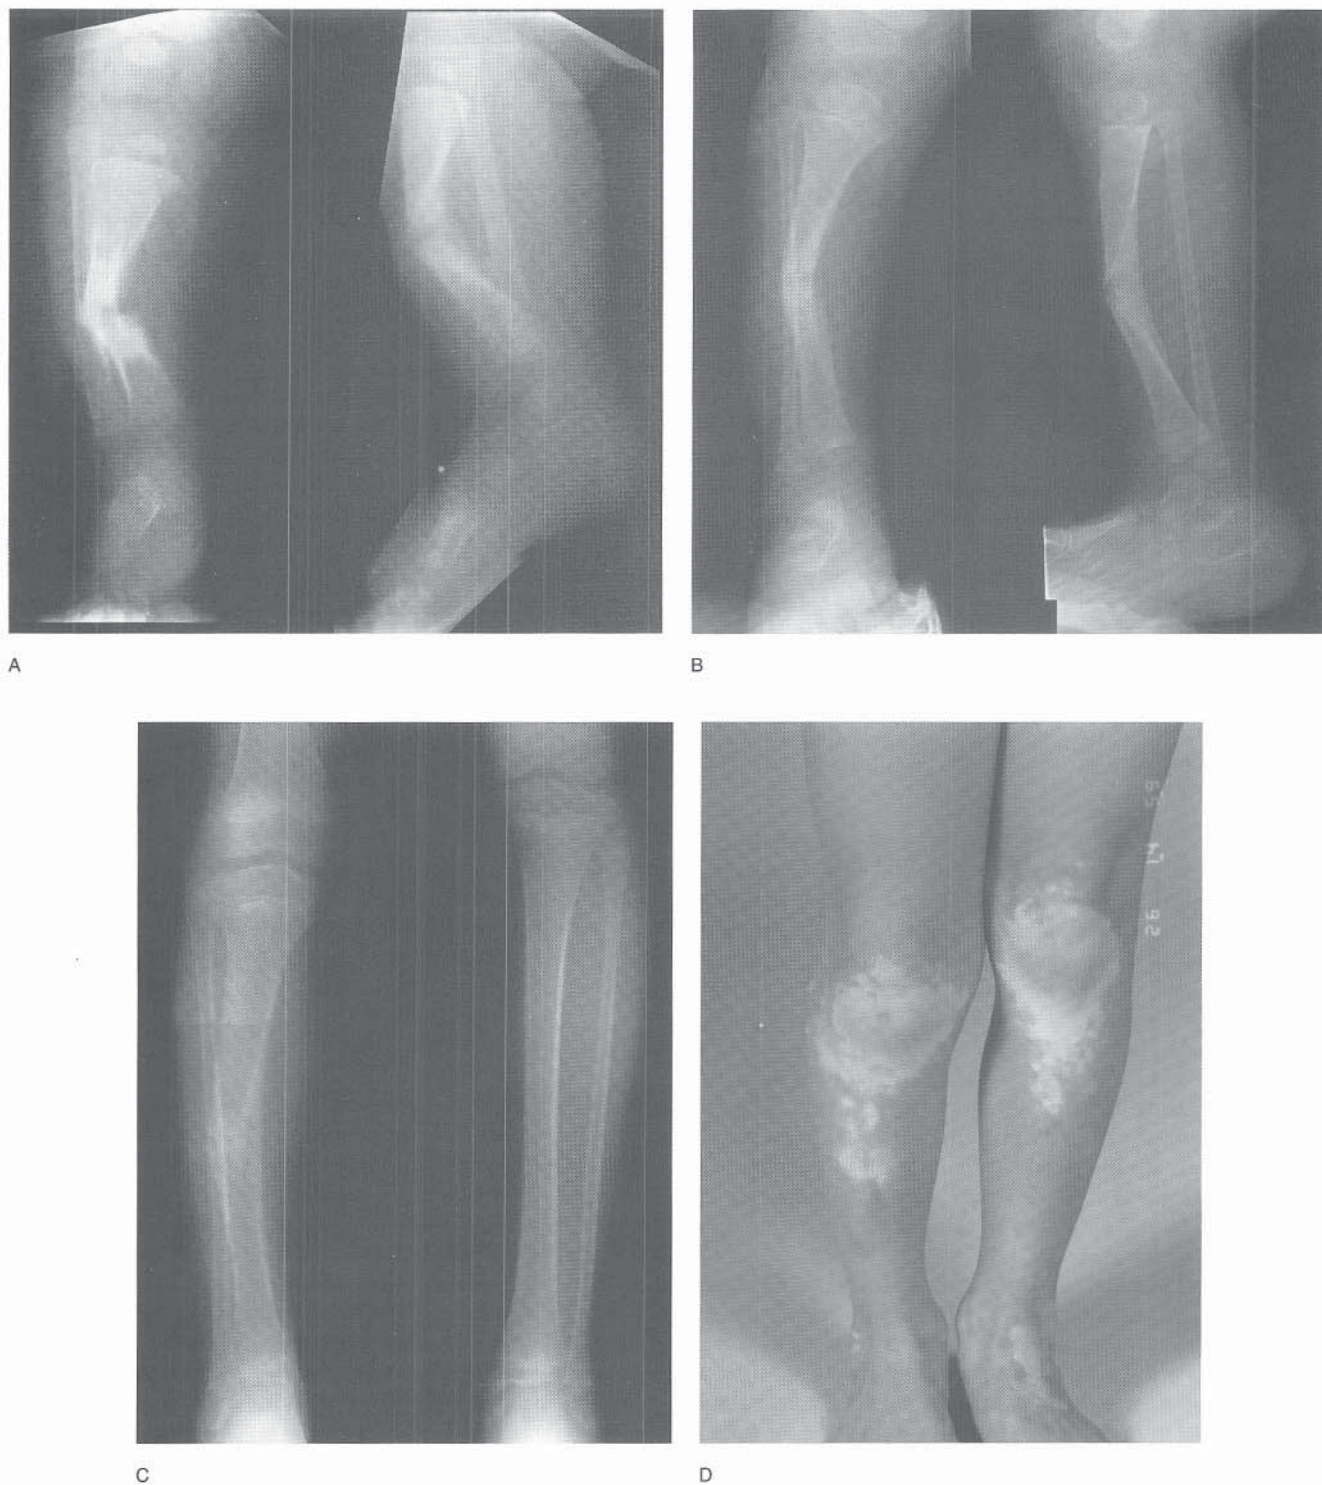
A, Radiographs of a newborn with a benign anterolateral bow. Note the callus in the concavity of the tibia, and the straight uninvolved fibula. B, Appearance at age 18 months. Remodeling of the callus in the concavity of the deformity continues. C, Appearance at age 9. The deformity has further remodeled. There is 4.5 cm shortening. The patient is fully active. D, Clinical appearance (the vitiligo is unrelated).
